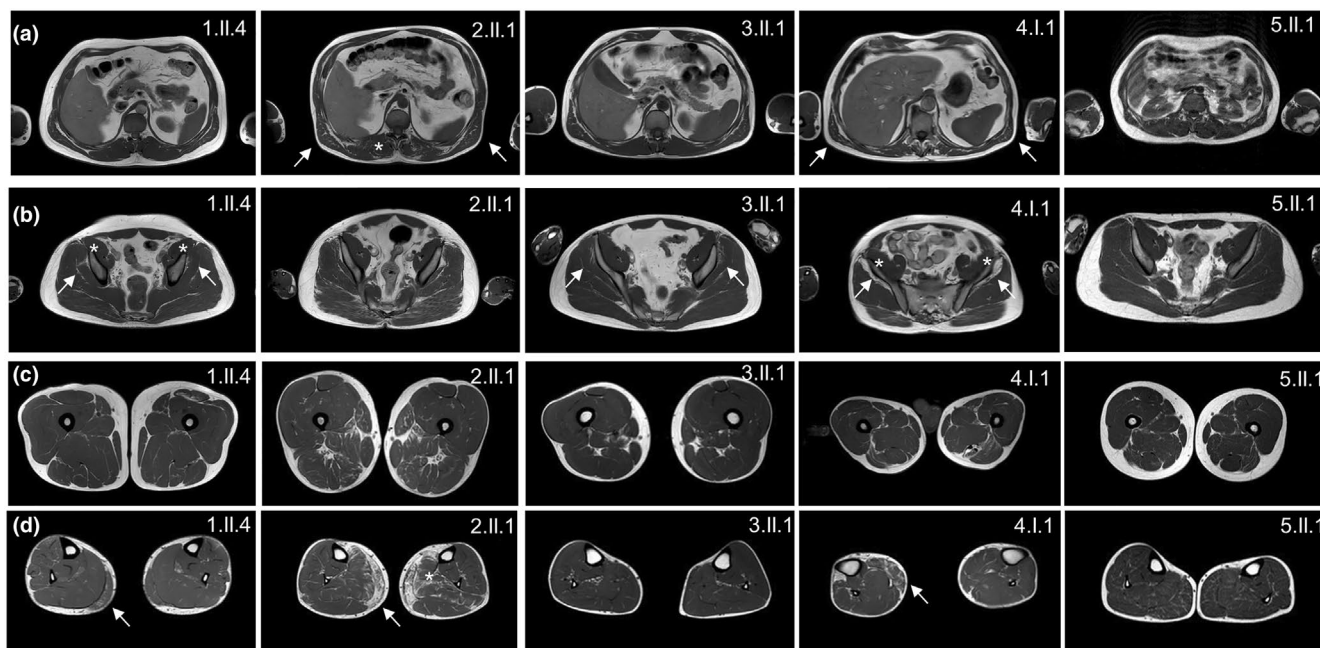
MRI patterns in *RYR1* p.Leu2286Val patients. (a) Latissimus dorsi was mildly affected in patients 2.II.1 and 4.I.1 (white arrow). Paravertebral muscles were also involved in patient 2.II.1 (asterisk). (b) Glutei minimum involvement (white arrow), as well as iliacus hypertrophy (asterisk), were present in patients 1.II.4, 3.II.1 and 4.I.1. (c) In the thighs, the posterior compartment was more affected than the anterior, especially sartorius, adductor magnus and biceps femoris. Thigh hypertrophy was present in 1.II.4, 3.II.1 and 2.II.1. (d) In the legs, medial gastrocnemius (white arrows) was affected in patients 1.II.4, 2.II.1 and 4.I.1; soleus in patient 2.II.1 (asterisk) and tibialis anterior in patient 4.I.1.
